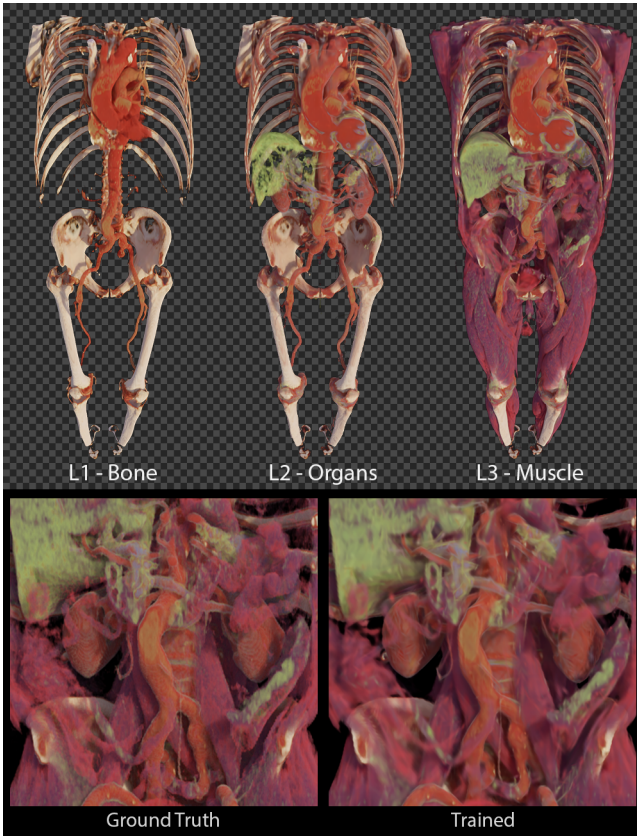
Fullbody CT scene consisting of the three layers Bone, Organs and Muscle. Rendered with Unity and clustering compression applied. Structures are largely present, but colors are smoothed.
